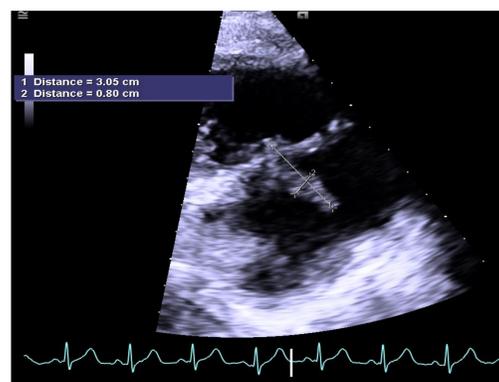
Transthoracic echocardiogram (TTE) showing vegetation in the tricuspid valve.
